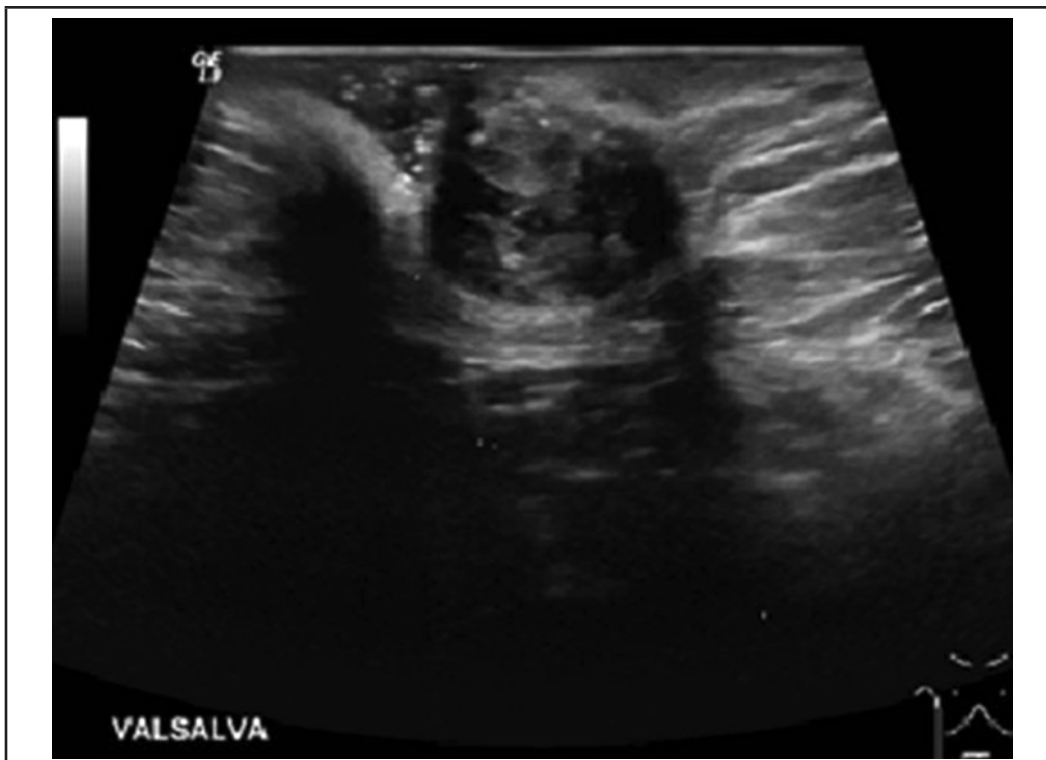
The ultrasound demonstrates a 1.7 x 1.5 x 1.3cm pocket containing herniated tissue contiguous and isoechoic to the peritoneal fat via a subcentimeter fascial defect. No signs of incarcerated bowel. Impression: Uncomplicated fat-containing umbilical hernia.
